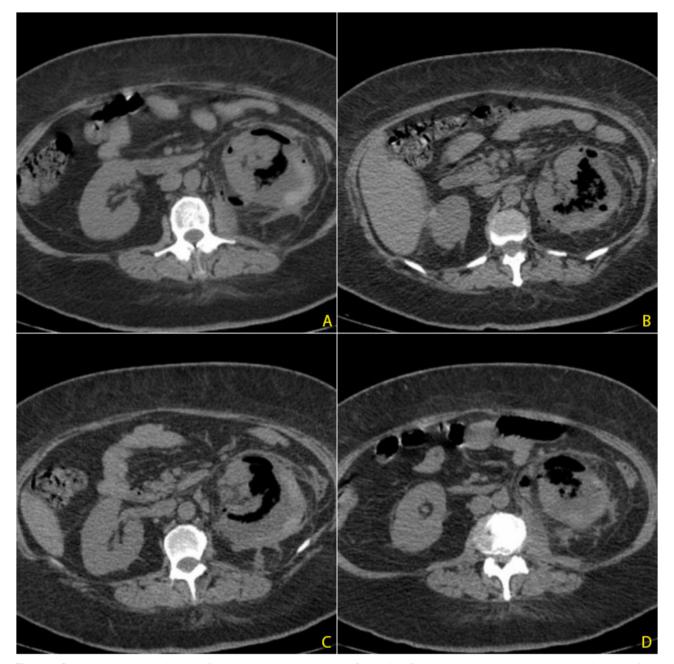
Computed tomography images of the abdomen without contrast. Panels A to D in cross section showing a volumetric increase of the left kidney, with signs of gas collections and perirenal blurring.
